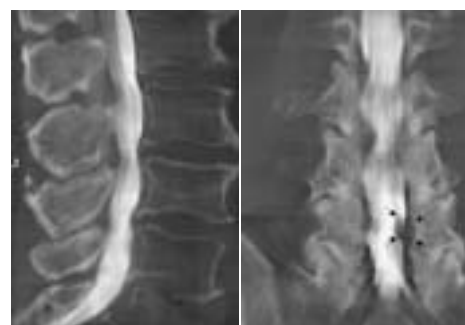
Myelo-Flat-panel CT in a patient with left lateral disc herniation. The herniated disc is nicely shown in the coronal MPR reconstruction (arrows). Note the excellent display of bony structures.
